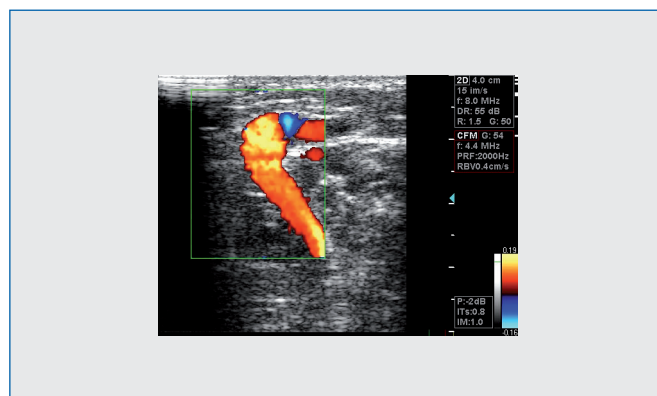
Identification with color duplex ultrasound of an incompetent calf perforator vein.
